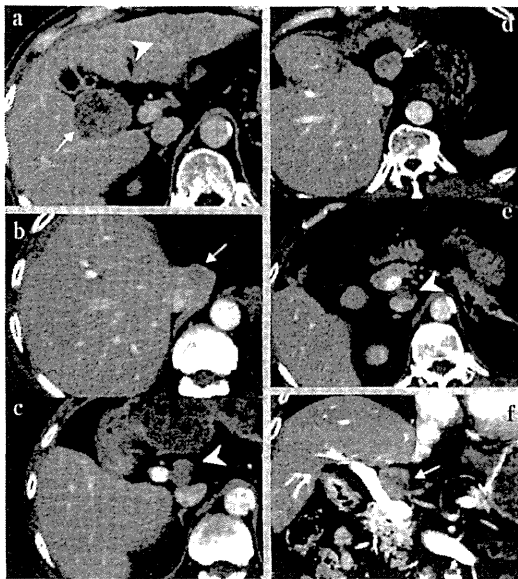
a: First operation. Abdominal computed tomography (CT) showing two tumors in left lateral lobe (arrowhead) and segment 5 (arrow).
